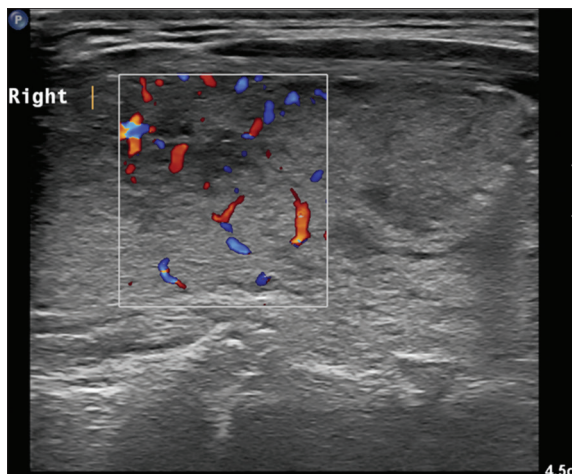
The thyroid ultrasound of case 1 showing a picture of active thyroiditis mainly at the right thyroid lobe and to less extent at the left lobe with reactive lymphadenopathy
